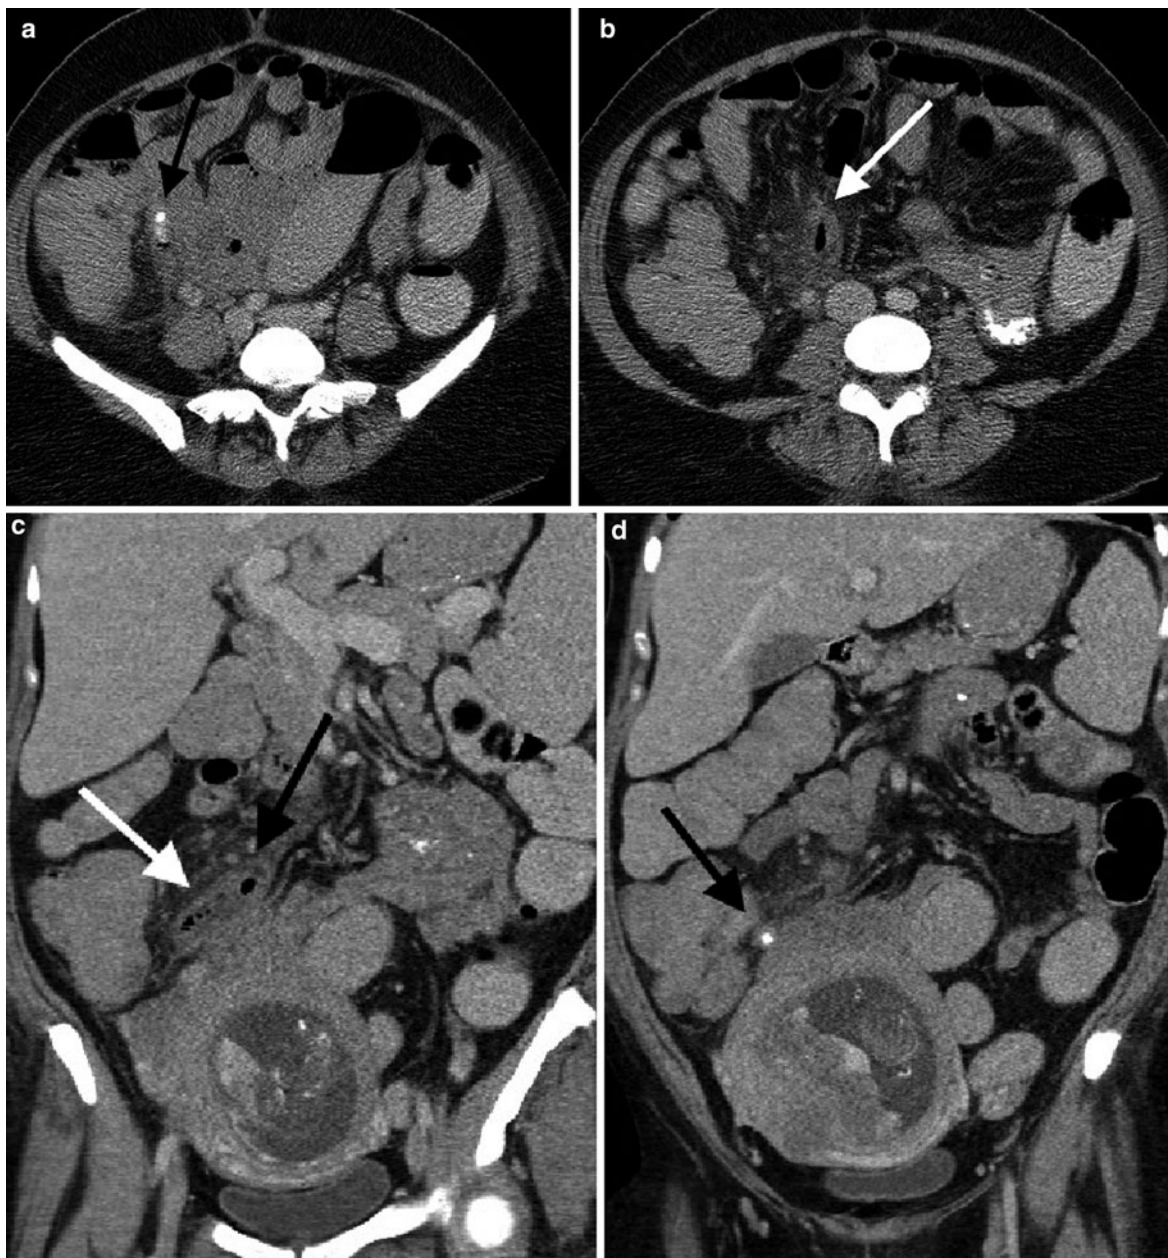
CT of 17-week pregnant patient with abdominal pain. Surgeons insisted on CT imaging. a Transverse image with intravenous and oral contrast shows a dilated inflamed appendix containing appendicoliths (*black arrow*). The tube current was reduced by 30% for this acquisition, b Transverse image in the same patient shows a periappendiceal
